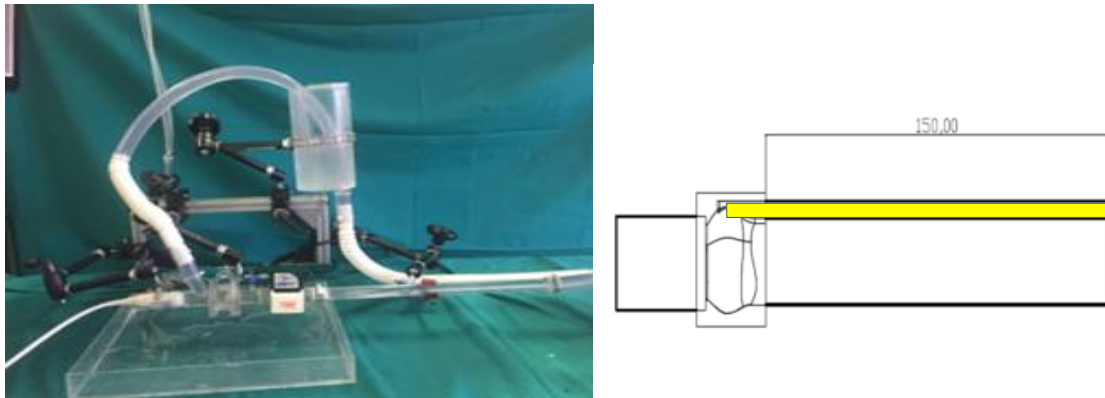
Left. Circuit set-up with the doppler probe. Right. Cylindrical section of 25 mm of diameter and 150 mm long with related port (in yellow) to measure the pressure.
